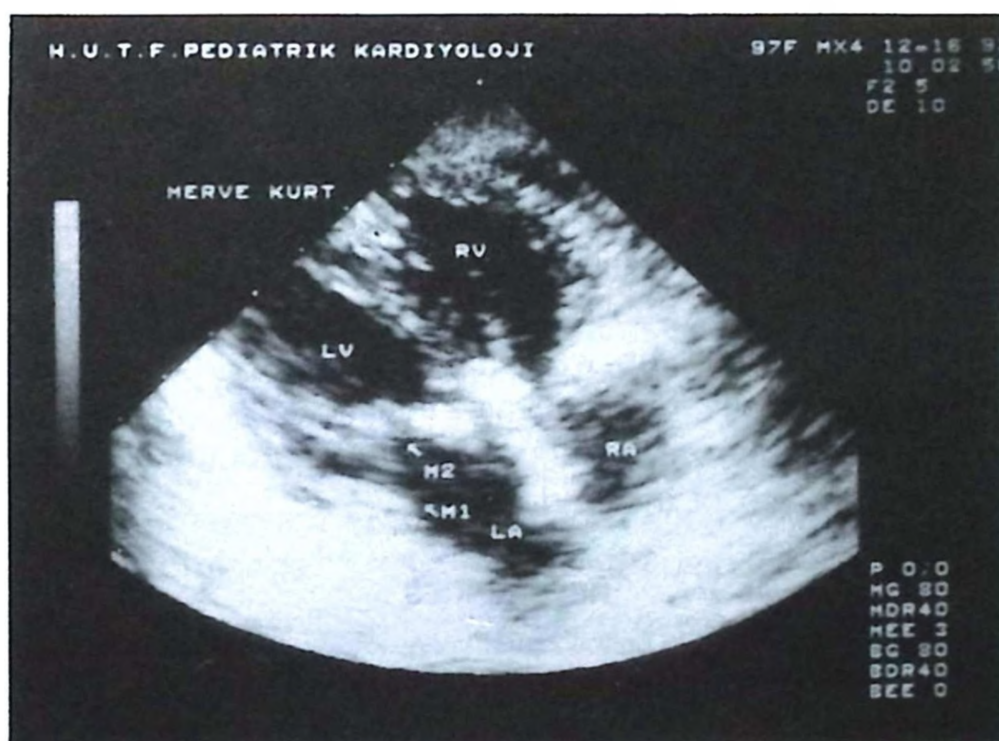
Postoperative echocardiography showing double orifice of the mitral valve.
